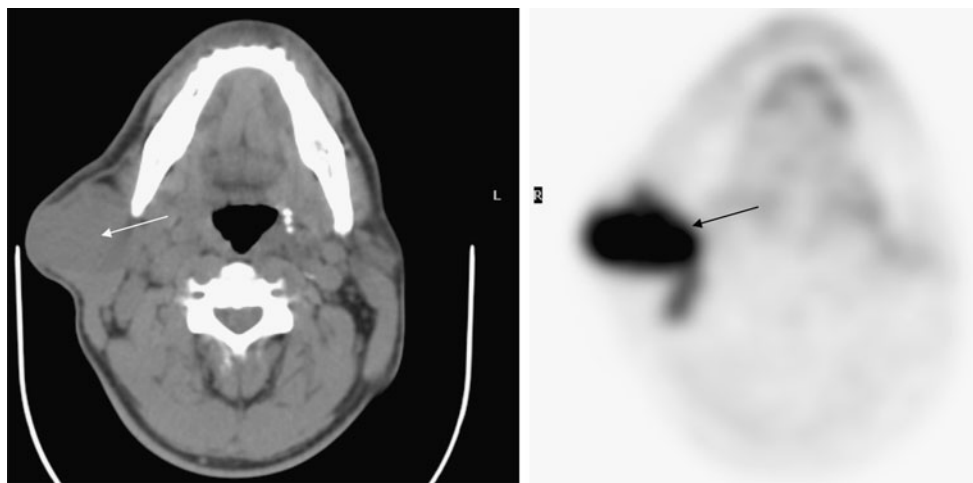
Parotid NHL in a 49-year-old man with AIDS. Transaxial images of FDG PET-CT show a large mass with intense uptake (SUV 13) in the right parotid gland (*arrows*). Parotid is the most frequently involved salivary gland in NHL
